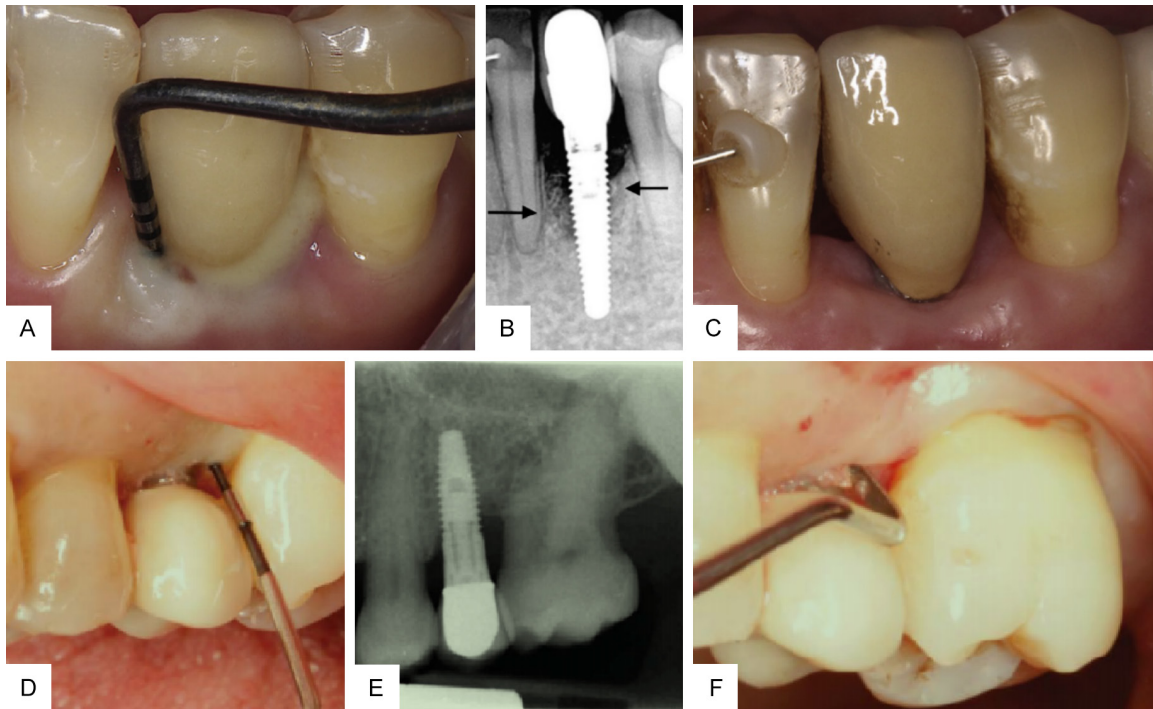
Clinical and radiographic images of a typical case before and after treatment. A. Preoperative clinical view showing peri-implantitis associated with chronic periodontitis, with a peri-implant pocket depth of 13 mm, accompanied by bleeding and exudate; B. Preoperative radiograph revealing a severe circumferential bone defect around the implant (indicated by the arrow); C. Postoperative clinical view at 1 month showing improved peri-implant soft tissue condition, with the pocket depth reduced to approximately 3 mm and no bleeding on probing; D. Preoperative clinical view of early peri-implantitis associated with periodontitis, with a peri-implant pocket depth of 15 mm; E. Preoperative radiograph displaying a bone defect around the implant; F. Postoperative clinical view at 1 month demonstrating improved peri-implant soft tissue recovery, with the pocket depth decreased to 4.5 mm and minimal bleeding on probing.
